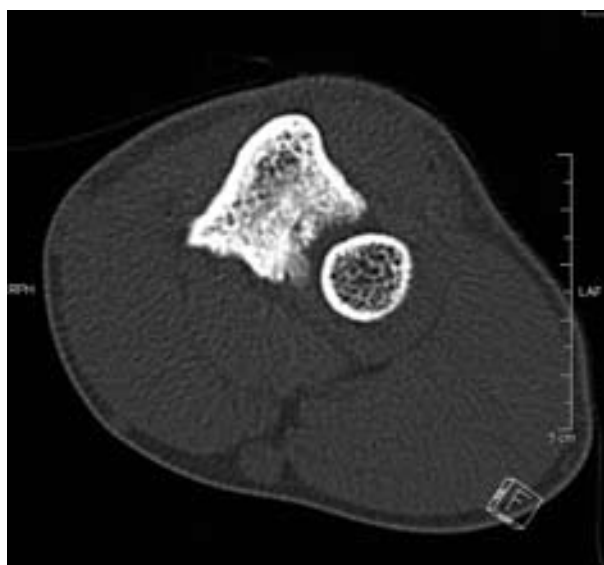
Axial slide of the preoperative CT-scan: Small abnormality of the proximal ulna at the proximal radio-ulnar joint.
